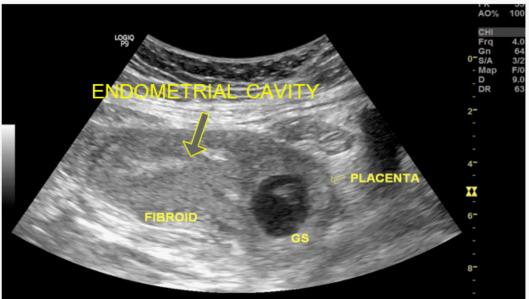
Transabdominal ultrasound showed gestational sac in the antero-inferior wall of the uterus. The uterine cavity is empty. Incidental finding of fibroid at posterior body of uterus.
